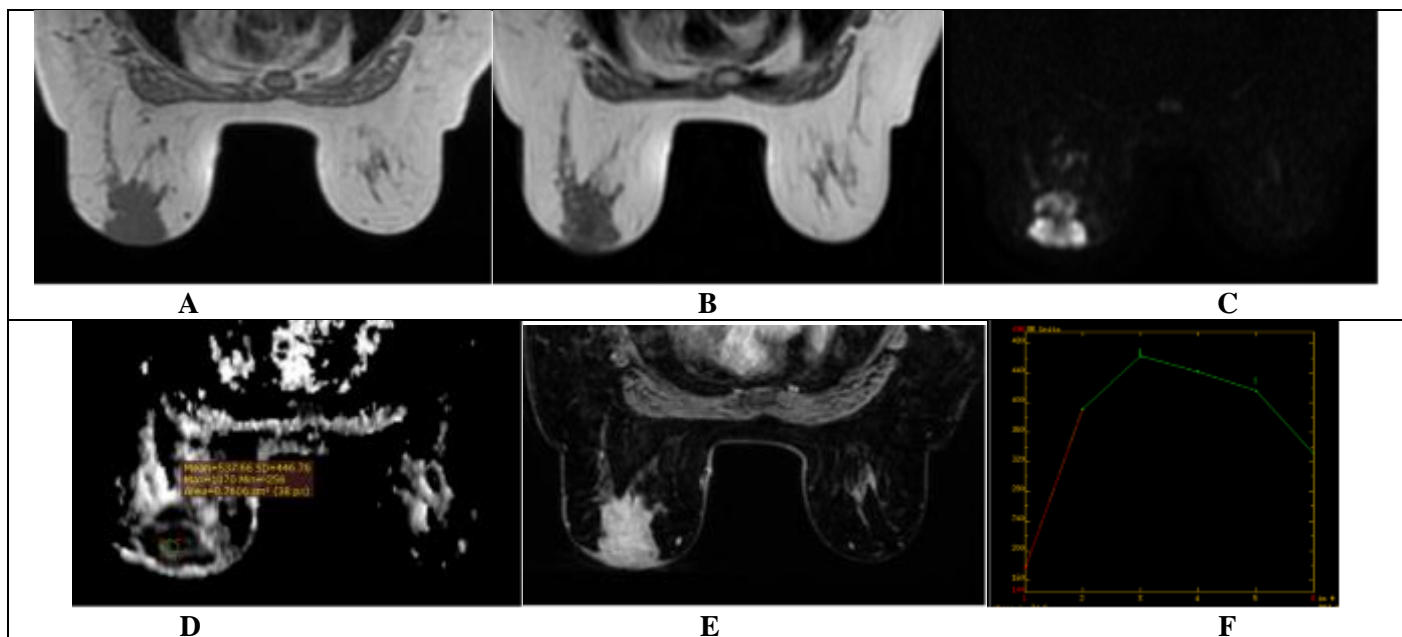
Case 2, Left breast invasive ductal carcinoma in a 55-year-old female patient. (A) Axial T1WI shows an ill-defined mass with spiculated margins at the retro-areolar region of the left breast displaying isointense signal to the surrounding glandular tissues. (B) Axial T2WI shows hypointense signal. (C) Axial DWI sequence ($b=1000$) shows hyperintense signal. (D) Axial ADC map shows hypointense signal with calculated mean ADC value = $0.54 \times 10^{-3} \text{ mm}^2/\text{s}$. (E) Post-contrast series displays heterogeneous enhancement. (F) Time-signal intensity curve reveals type III curve (wash-out pattern). The mass was correctly classified as malignant (BIRADS 5) according to combined imaging protocol.
